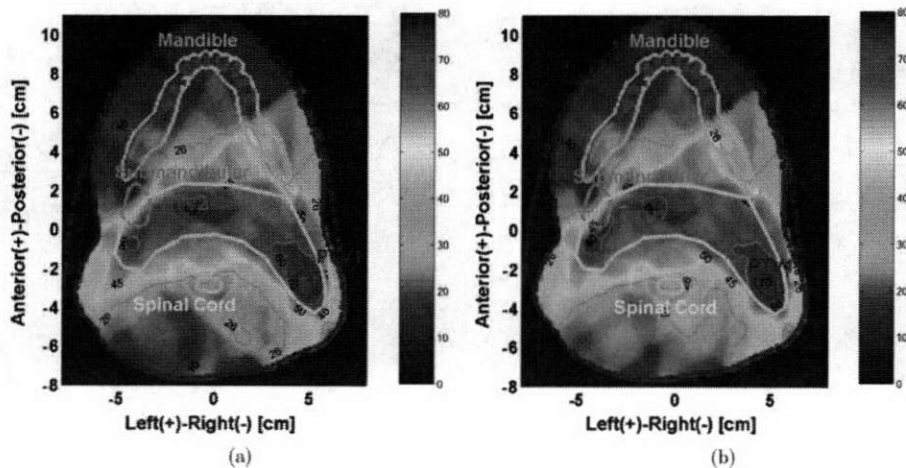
Overlay of axial CT isodose curves (10, 26, 45, 50, 60, 70 Gy), dose colourwash, and structures (PTV1-blue, PTV2-orange, spinal cord-yellow, right submandibular gland-green, mandible-cyan) for the globally optimal solutions obtained by (a) the LP_{PWL} model and (b) the $LP_{PWL+CVaR}$ model.
